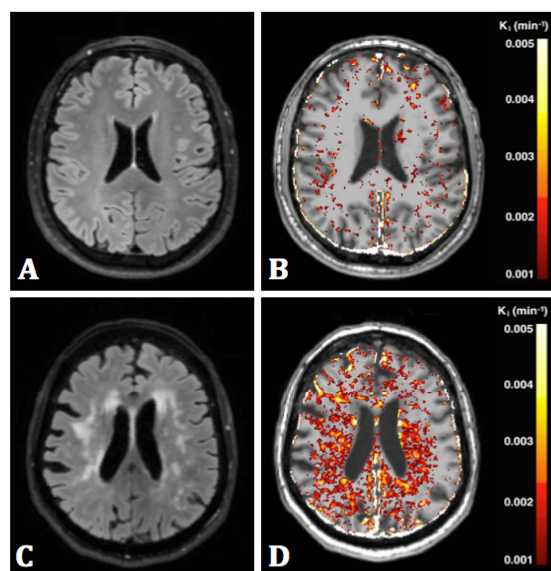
Example of a T2-weighted (FLAIR) image and K_i map superimposed on a T1-weighted image of a healthy control (A,B respectively) and a patient with cSVD (C,D respectively). Here only $K_i > 0.001 \text{ min}^{-1}$ is shown. It can be appreciated that the patient with cSVD shows stronger leakage than the control.
